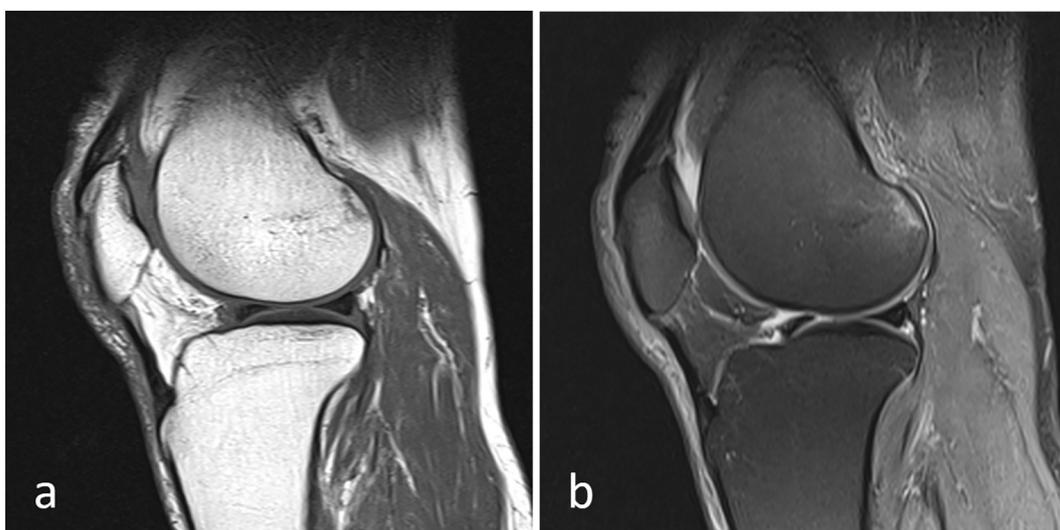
Sagittal T1- (a) and proton density-weighted MRI with fat saturation (b) showing a small insufficiency fracture of the posterior non-weight bearing lateral femoral condyle with mild surrounding marrow edema in a 69-year-old man.
